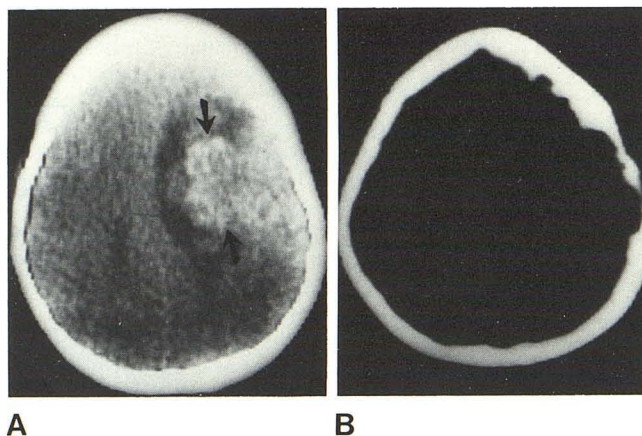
Secondary craniocerebral neuroblastoma; intratumoral hemorrhage into calvarial metastasis with intracerebral extension of hemorrhage. A, CT scan without contrast agent injection. Irregular hemorrhagic mass (arrows) surrounded by edematous zone. B, Higher section, at bone density setting. Several lytic lesions erode both tables of skull. Area is contiguous with site of hemorrhage in A.
